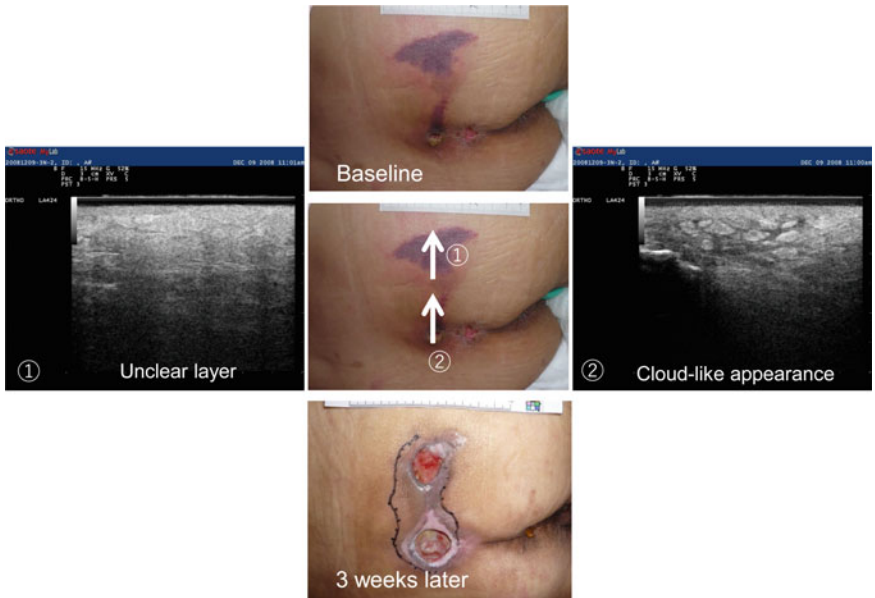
Ultrasonography for worsening deep tissue injury
